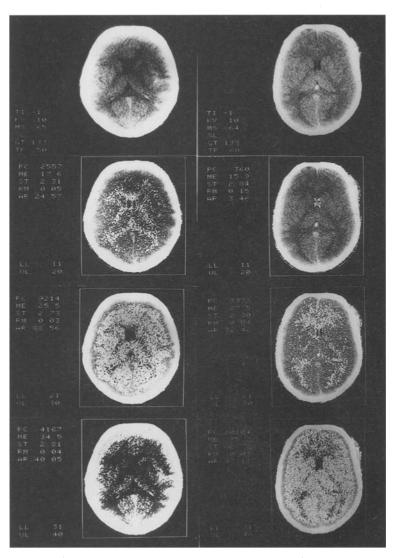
CT scans of edematous (on the left) and hyperemic (on the right) brain swelling using the "Highlighting" program. Between 11 and 20 HU, the number of pixels illuminated is high in edema and low in hyperemia. On the other hand, between 31 and 40 HU the number of pixels illuminated is low in edema and high in hyperemia.
